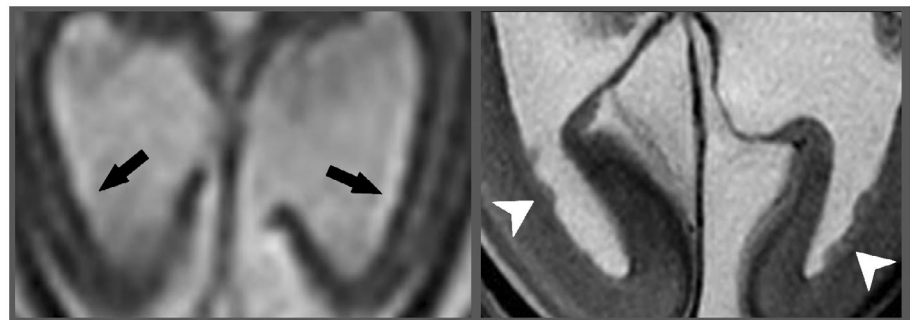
Periventricular nodular heterotopia. (A) axial T2-weighted image at 21 GW shows severe ventriculomegaly; notice smooth ependymal walls (arrows) with no evidence of heterotopia. (B) postmortem axial T2-weighted image clearly reveals multiple bilateral heterotopic nodules (arrows)
